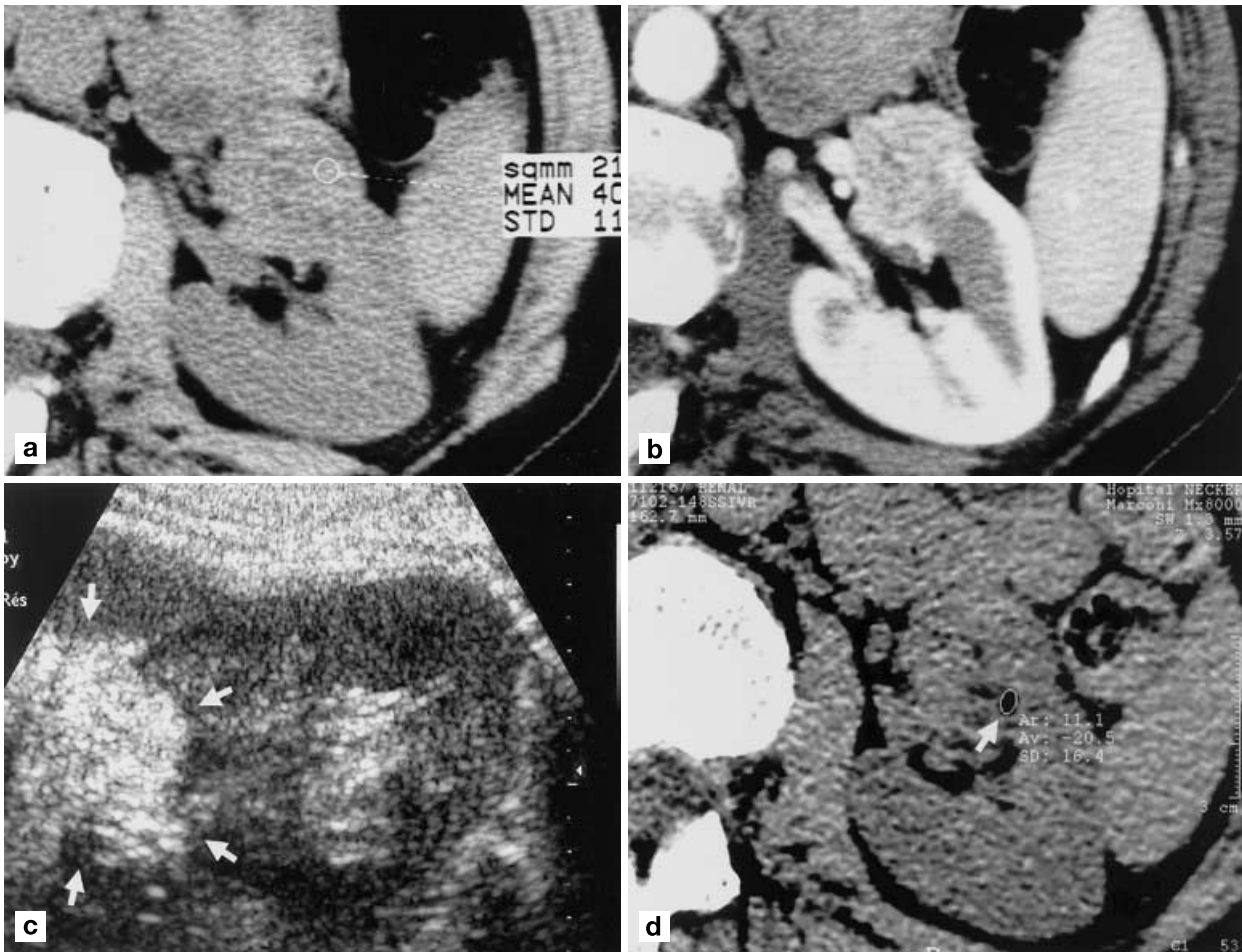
Atypical angiomyolipoma with minimal fat component. a Pre- and b postcontrast CT using a standard protocol (5-mm slice thickness) failed to demonstrate intratumoral fat. c Ultrasound showed suggestive hyperechoic pattern (*arrows*) that prompted repeat CT examination using thinner collimation. d Unenhanced CT scan using 3-mm slice thickness clearly demonstrates a tiny intratumoral island of fat tissue which prevents surgery
